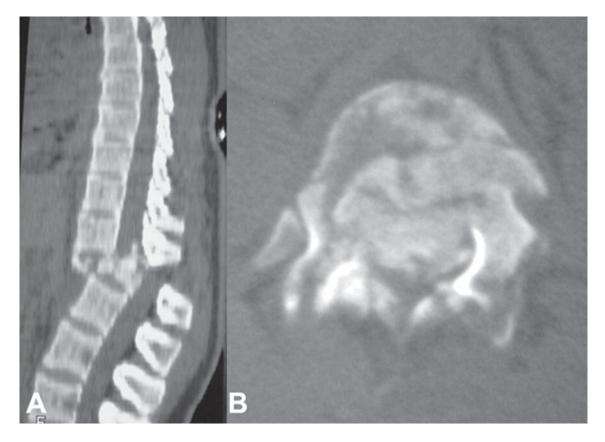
Preoperative (A) sagittal and (B) axial CT scan of the thoracolumbar spine show significant canal compromise.
